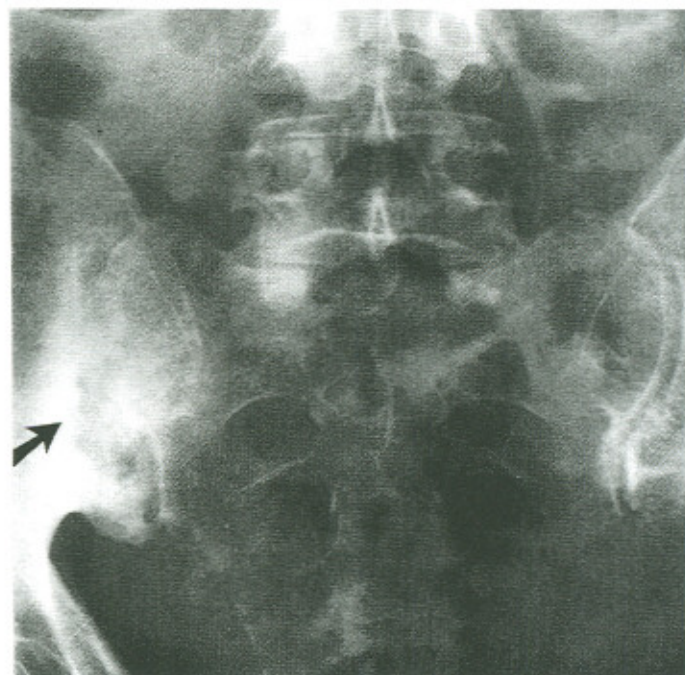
(b) Radiograph of SI joints of same female, two years after that shown in Figure 6(a). Her condition is now chronic. Note the erosion of joint margins, joint space widening and peri-articular sclerosis which are now apparent at the left sacroiliac joint (arrow). The right side remains normal.
